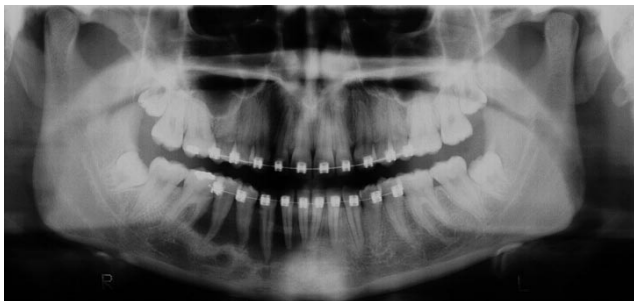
Subsequent orthopantomography examination (august, 01, 2001). The radiograph showed a radiolucency undefined lesion extending from region of the left mandibular central incisor to the right mandibular first molar.
